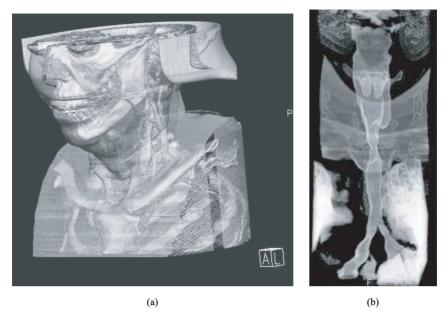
S-CT after iv. contrast injection, multiorgan display: "Volume Rendered" 3D reconstruction of the neck and upper chest in a patient suffering from a tracheal carcinoma where a tracheal stent was also implanted: (a) View from outside, (b) result after changing the opacity curve to a bronchographic appearance of the LTT. The implanted stent as well as the laryngeal cartilage are depicted by the dark areas.
